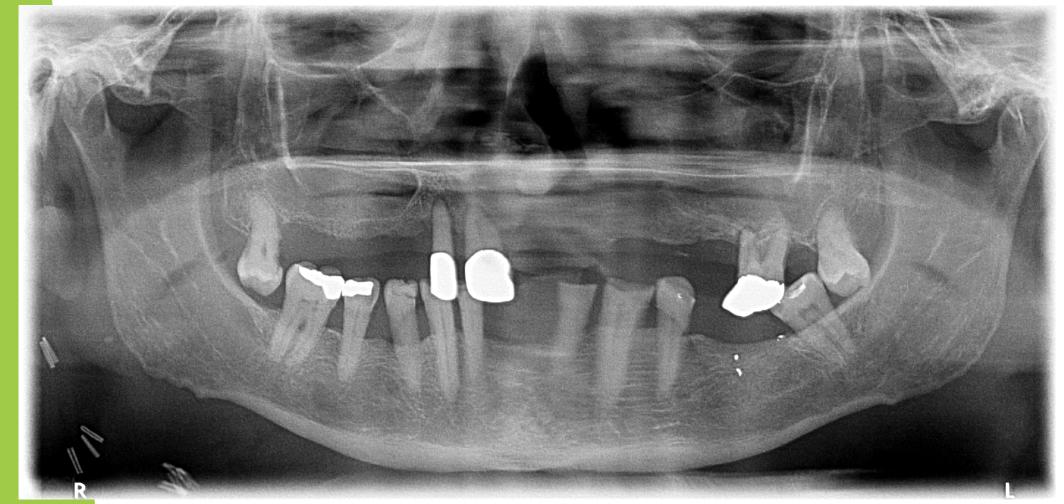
Dental orthopantomogram to assess remaining dentition including bone levels, presence of apical pathology and proximity of roots to adjacent structures. Intraoral views not tolerated due to gag reflex. Grade 1. Generalised horizontal bone loss to mid third of root length and to apical third at worst point (UL6). Apical radiolucency visible UR2, UR1, UL6 mesial root.
